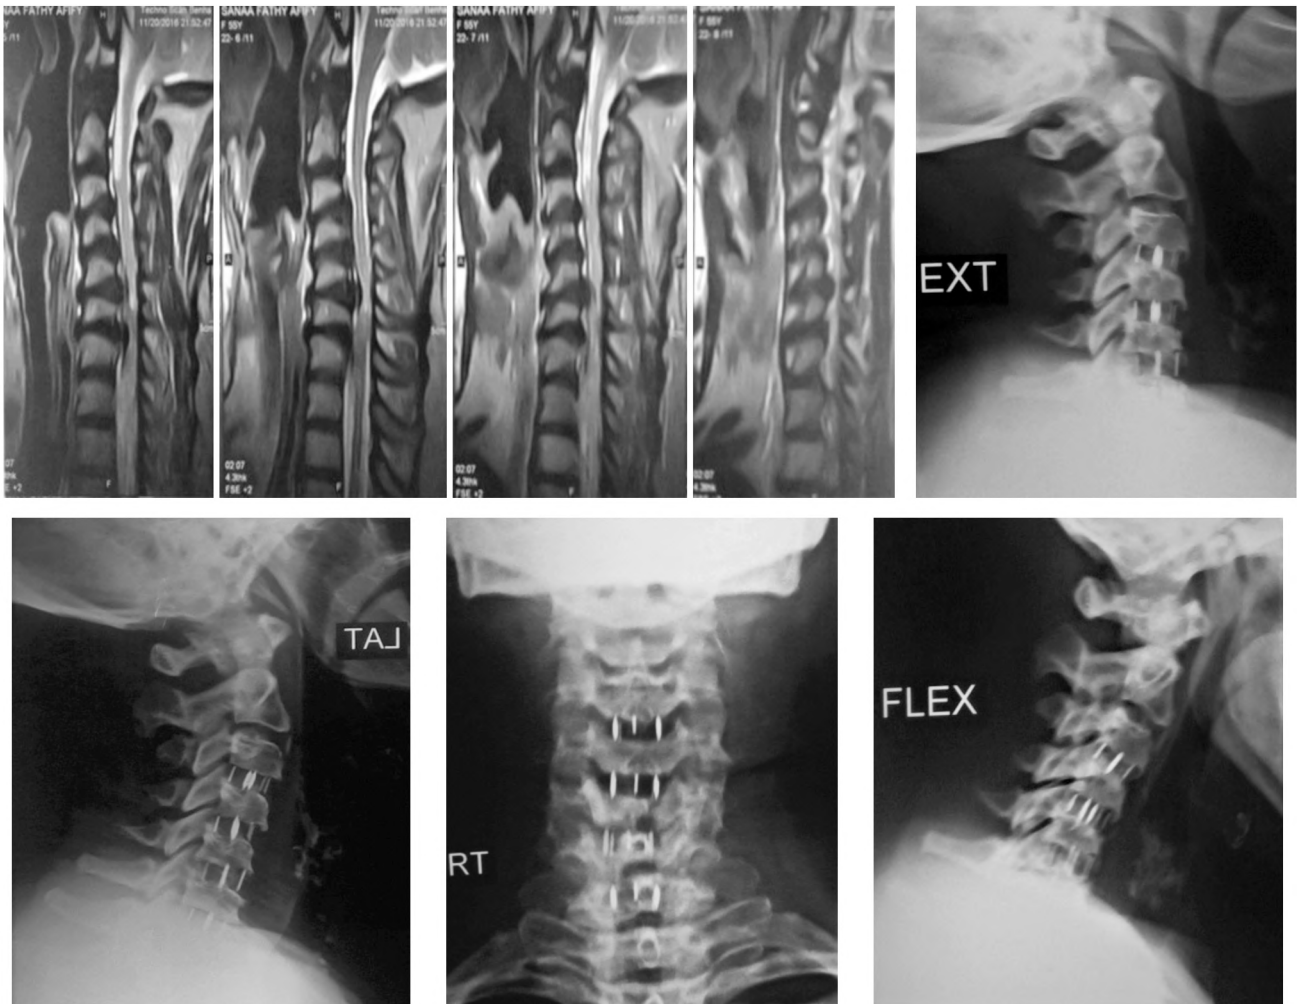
This female patient presented with radiculomyelopathy and quadriplegia more on the left side MRI pre-operative showed  $C_{3-4}$  to  $C_{6-7}$  cervical disc lesion with cord compression mainly opposite  $C_{5-6}$ . Plain X-ray AP and lateral of early post-operative period and to the right flexion and extension radiograph at 12 months after surgery showing good fusion and stability during flexion and extension. Patient clinically showed excellent improvement.
